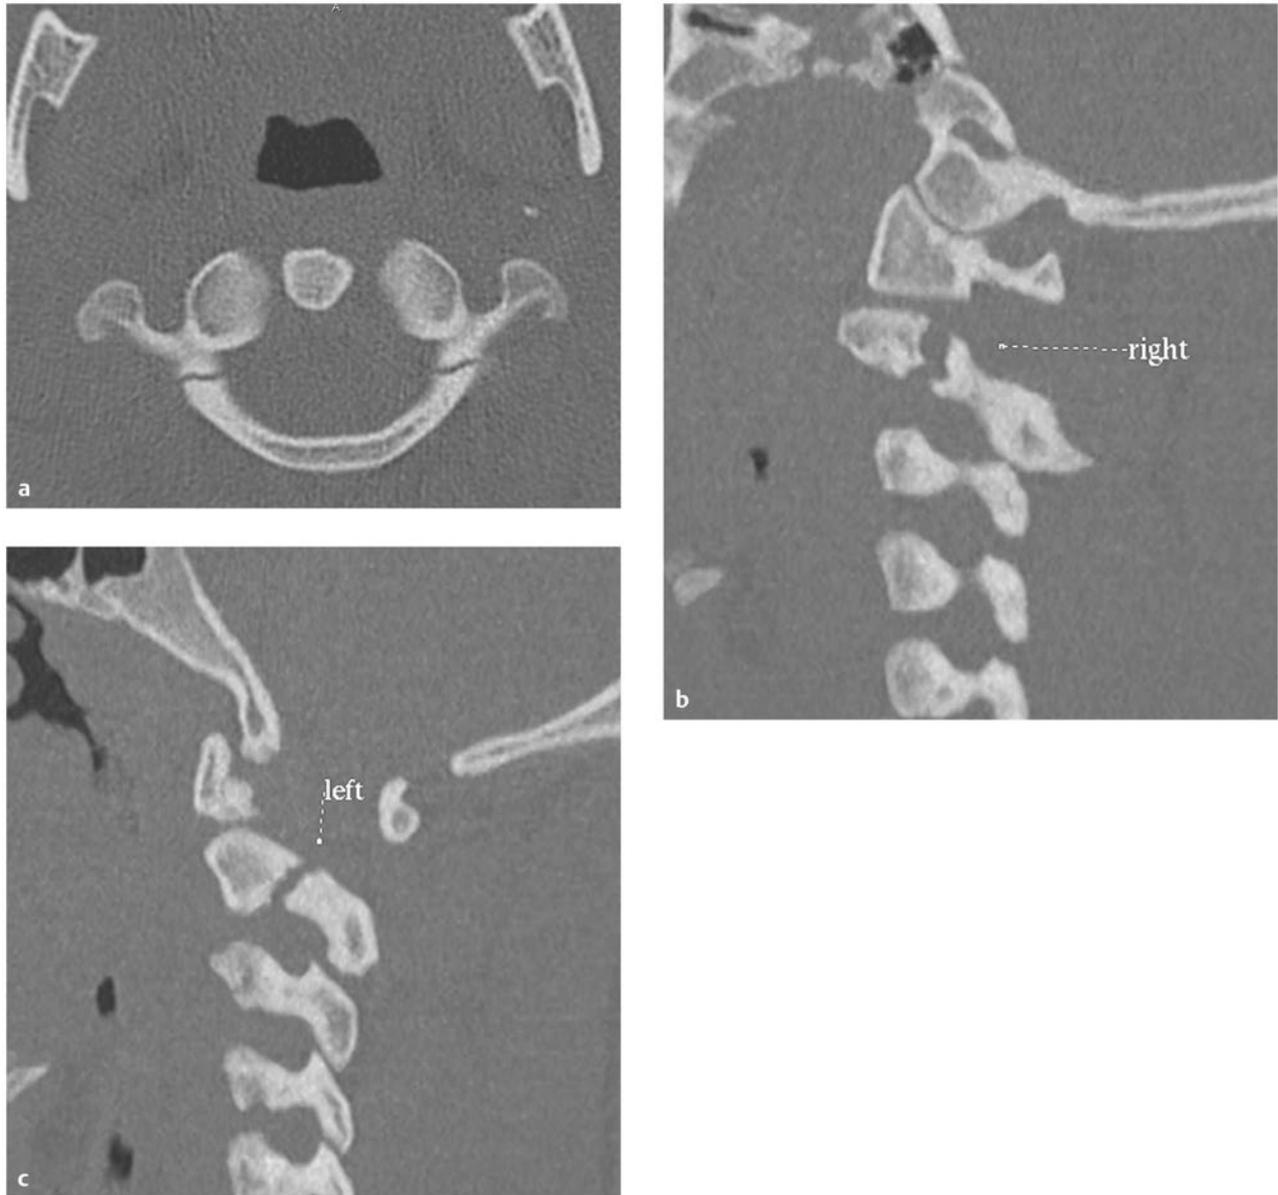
Hangman's (C2 pars) fracture. (a) Axial and (b,c) parasagittal computed tomographic scans demonstrating a classic hangman's fracture with bilateral C2 pars involvement. Most fractures of this type can be treated with a rigid cervical collar if there is minimal displacement of the C2 vertebral body on C3. If there is more than 3 mm of displacement, external immobilization with a halo or Minerva brace should be strongly considered.
